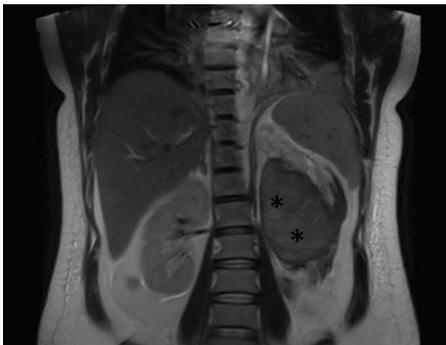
Non-Contrast enhanced abdominal MRI showing a 90x110 mm retroperitoneal hematoma adjacent to the posterior of the left kidney in T2-weighted images (asterisks). An evidence of retroperitoneal hematoma is the displacement of the left kidney.
